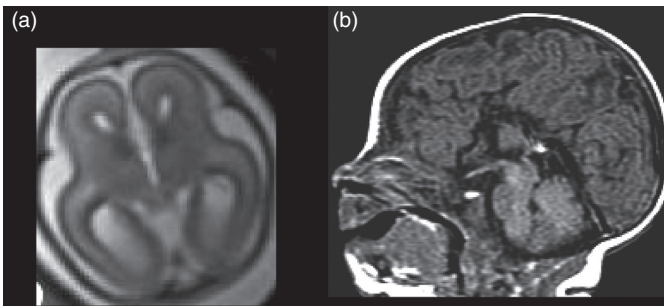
Agenesis corpus callosum on (a) fetal axial T2 and (b) neonatal sagittal T1 MRI (see Fig. 18.1. f,g) [50].
